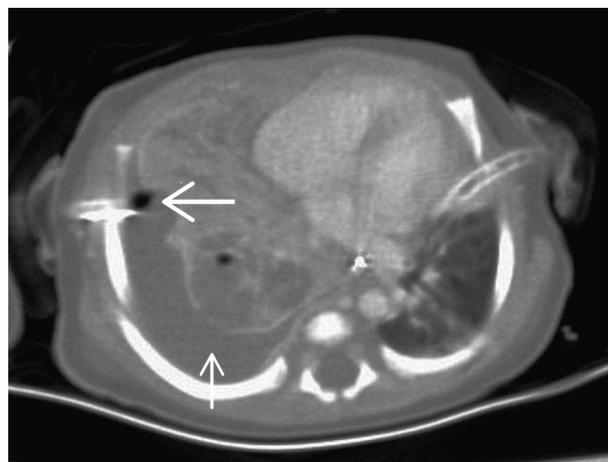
The first chest computed tomography scan of the patient showing necrotizing pneumonia of the right lung with bronchopleural fistula (abnormal air collection; large arrow) and empyema formation (low-density fluid collection with fibrin content; small arrow).
